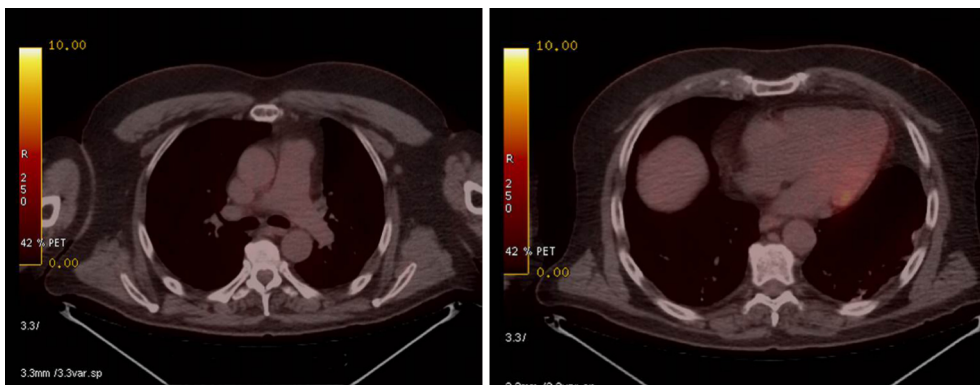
Thoracic positron emission tomography/computed tomography scan showing metastatic nodules (arrows).
